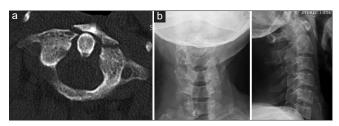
(a) Axial computed tomography scan from cervical spine at C1–C2 level. (b) AP and lateral plain radiograph; fracture of anterior arch of C1 detected by axial computed tomography, and missing in plain radiograph
